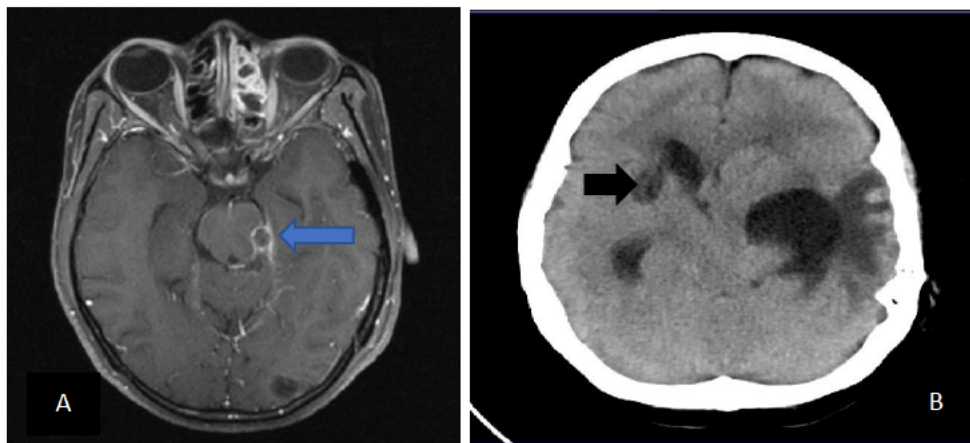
Post contrast T1W MRI brain scan (A) depicting a contrast enhancing inflammatory mass lesion (blue arrow), and a non-contrasted CT brain scan (B) depicting right anterior limb of internal capsule infarct (black arrow).
